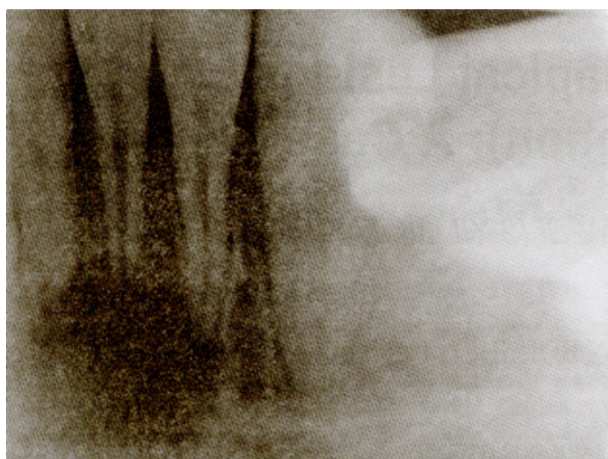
The radiographic diagnosis of case.
